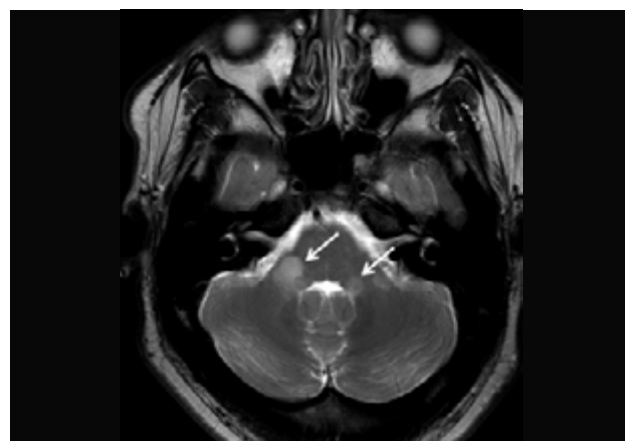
MRI of a 43-year-old woman presenting with ataxia. Axial T2WI showing hyperintense lesions in both middle cerebellar peduncles (arrows) in a patient subsequently diagnosed with multiple sclerosis.
